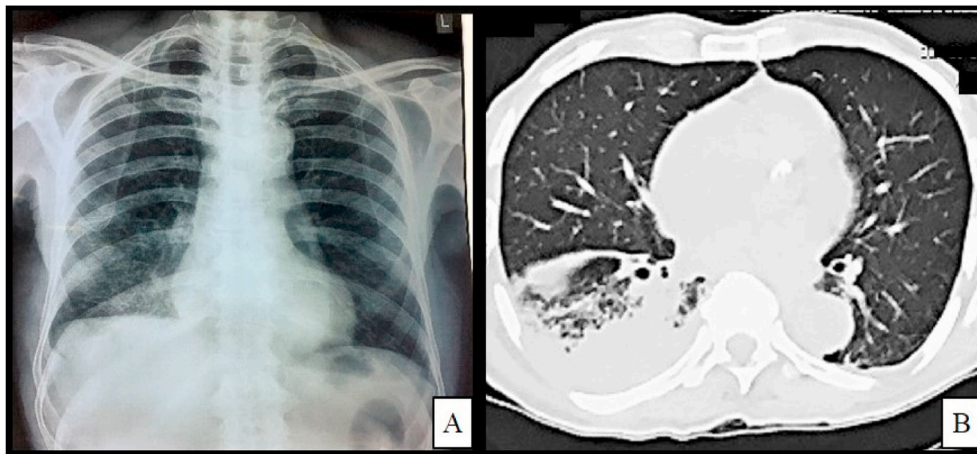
Chest Xray showing right sided non homogenous opacity (A) and CECT chest transverse section showing right posterior basal consolidation with effusion(B).
